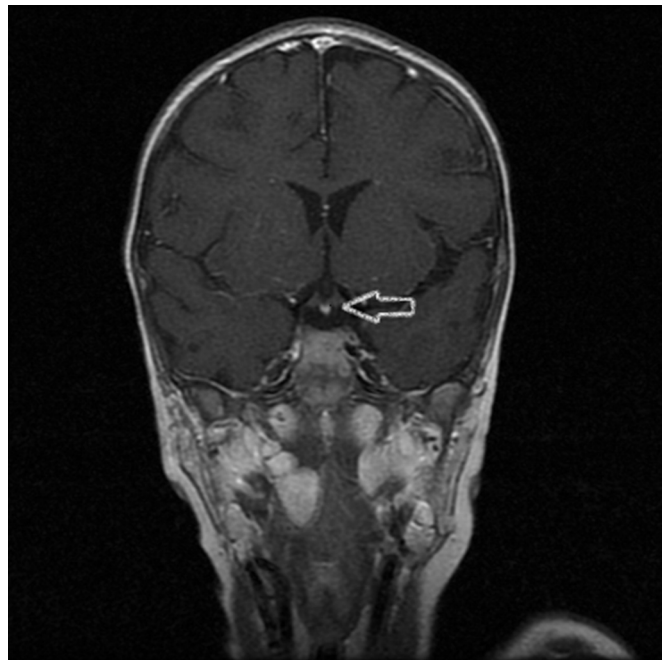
Coronal contrast enhanced T1-weighted image. Blunt ending infundibulum is seen.
